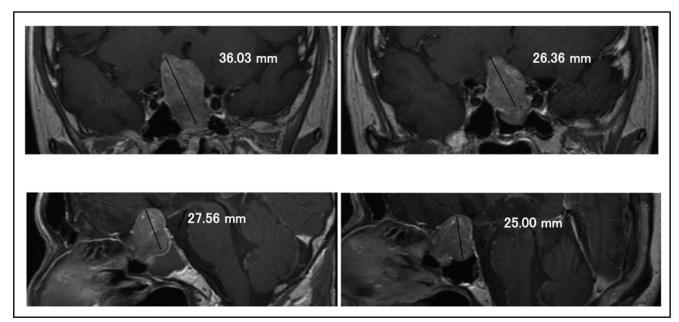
Case 1. Magnetic resonance imaging using gadolinium-based contrast medium. The tumor measured 36 mm before treatment, but it shrank to 26 mm at three months after administration of lanreotide.
